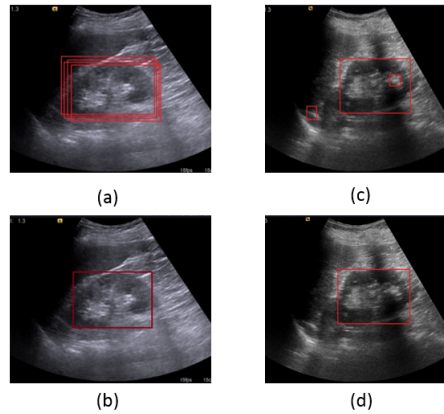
(a),(c) Multiple detection of kidney in ultrasound images, red boxes shows the region of interest for kidney. (b) Merging of Multiple detection in (a) to form single ROI. (d) Single ROI detection on (c) using threshold technique.
